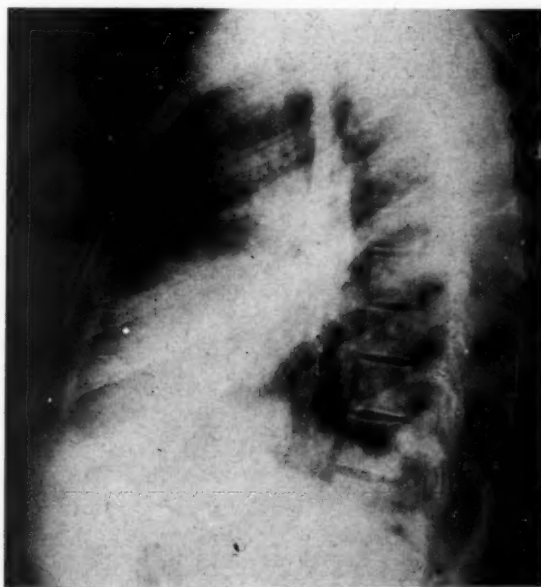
Lateral roentgenogram of chest taken at first admission, showing shadow of collapse of left lower lobe.
